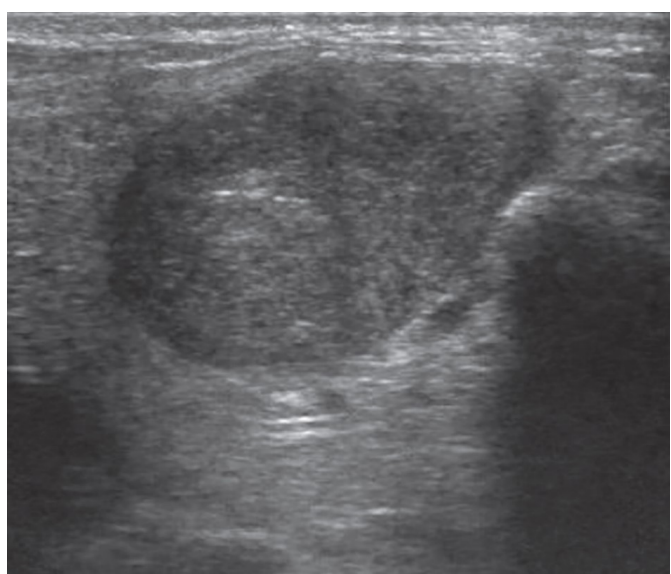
Sonographic image of an oval-shaped isoechoic pleomorphic adenoma.
